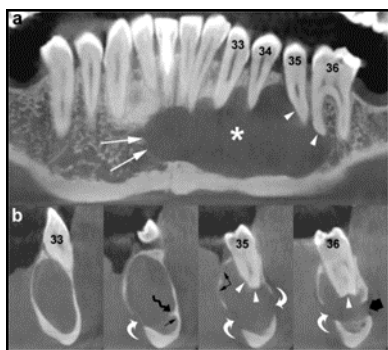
CBCT image of OKC
